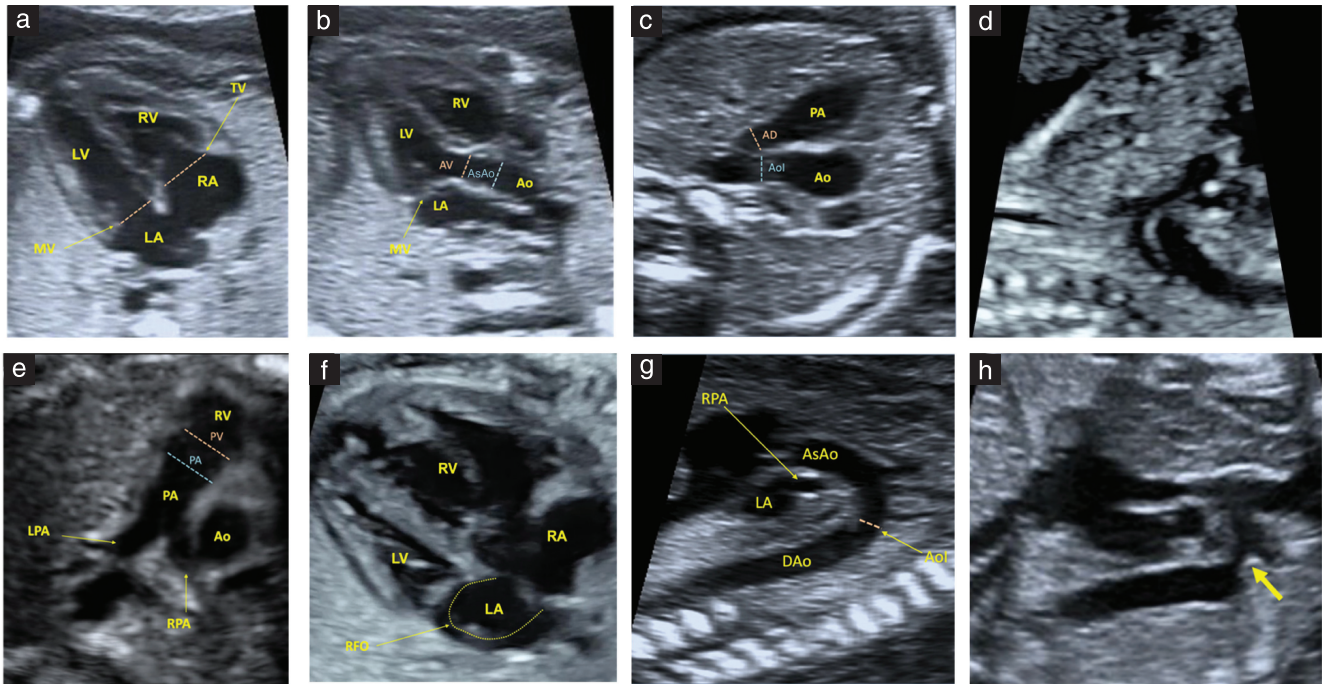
Ultrasound parameters obtained using B-mode that were evaluated as predictors of coarctation of aorta, including: (a) tricuspid valve (TV) and mitral valve (MV) diameters; (b) aortic valve (AV) and ascending aorta (AsAo) diameters; (c) arterial duct (AD) and aortic isthmus (AoI) diameters; (d) hypoplastic aortic arch; (e) pulmonary valve (PV) and main pulmonary artery (PA) diameters; (f) redundant foramen ovale (RFO); (g) AoI diameter in sagittal view; and (h) juxtaductal shelf (arrow). Dashed lines indicate diameters. Ao, aorta; DAo, descending aorta; LA, left atrium; LPA, left pulmonary artery; LV, left ventricle; RA, right atrium; RPA, right pulmonary artery; RV, right ventricle.
